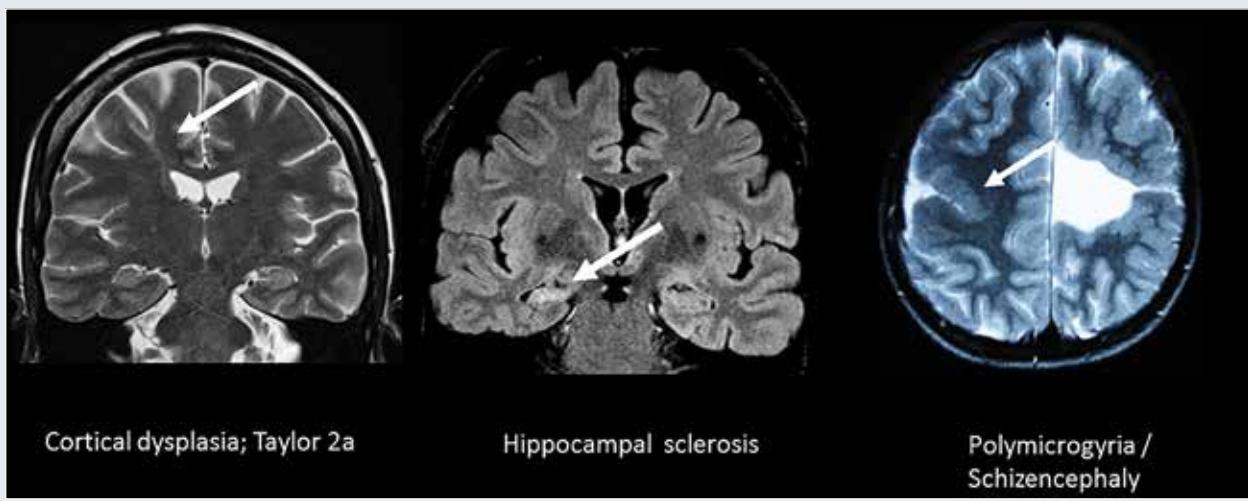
Imaging findings in specific epilepsy syndromes, Left: Juxta-cortical T2 hyperintense lesion (transmantle sign) in the cortical dysplasia Type Taylor 2a. Middle: FLAIR hyperintense and atrophic hippocampal formation in hippocampal sclerosis in mesiotemporal epilepsy (MTLE). Right: Inborn polymicrogyria / schizencephaly in Lennox-Gastaut syndrome.
